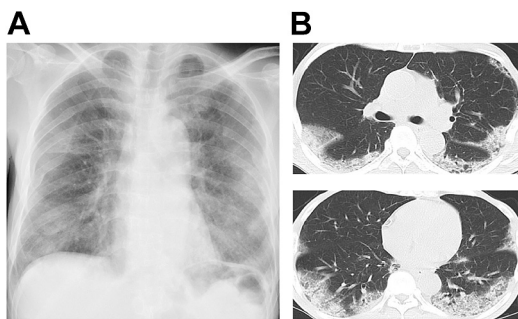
Chest X-ray (a) and high-resolution computed tomography (b) of case 1. Multiple reticulonodular infiltrates in the subpleural region and diffuse bilateral pulmonary infiltrates with ground-glass opacities of both lung fields were observed.
